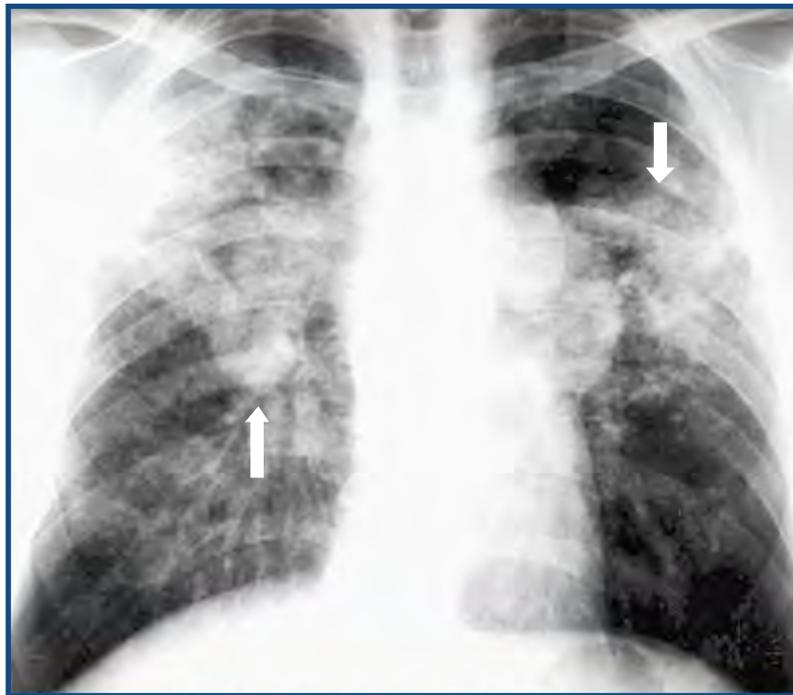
Chest radiograph showing Stage II Sarcoidosis with lymph node (arrow pointing up) and lung tissue involvement (arrow pointing down).
